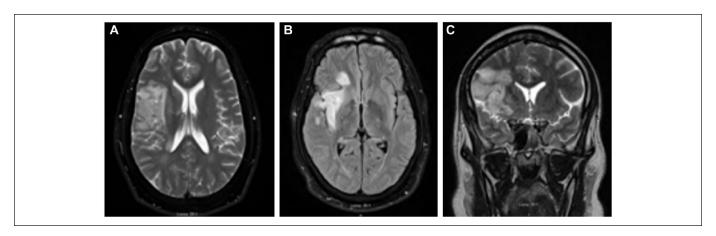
(A and B) Magnetic resonance imaging of the brain. Axial section shows an acute right middle cerebral artery infarct. (C) Coronal section shows corresponding middle cerebral distribution.
